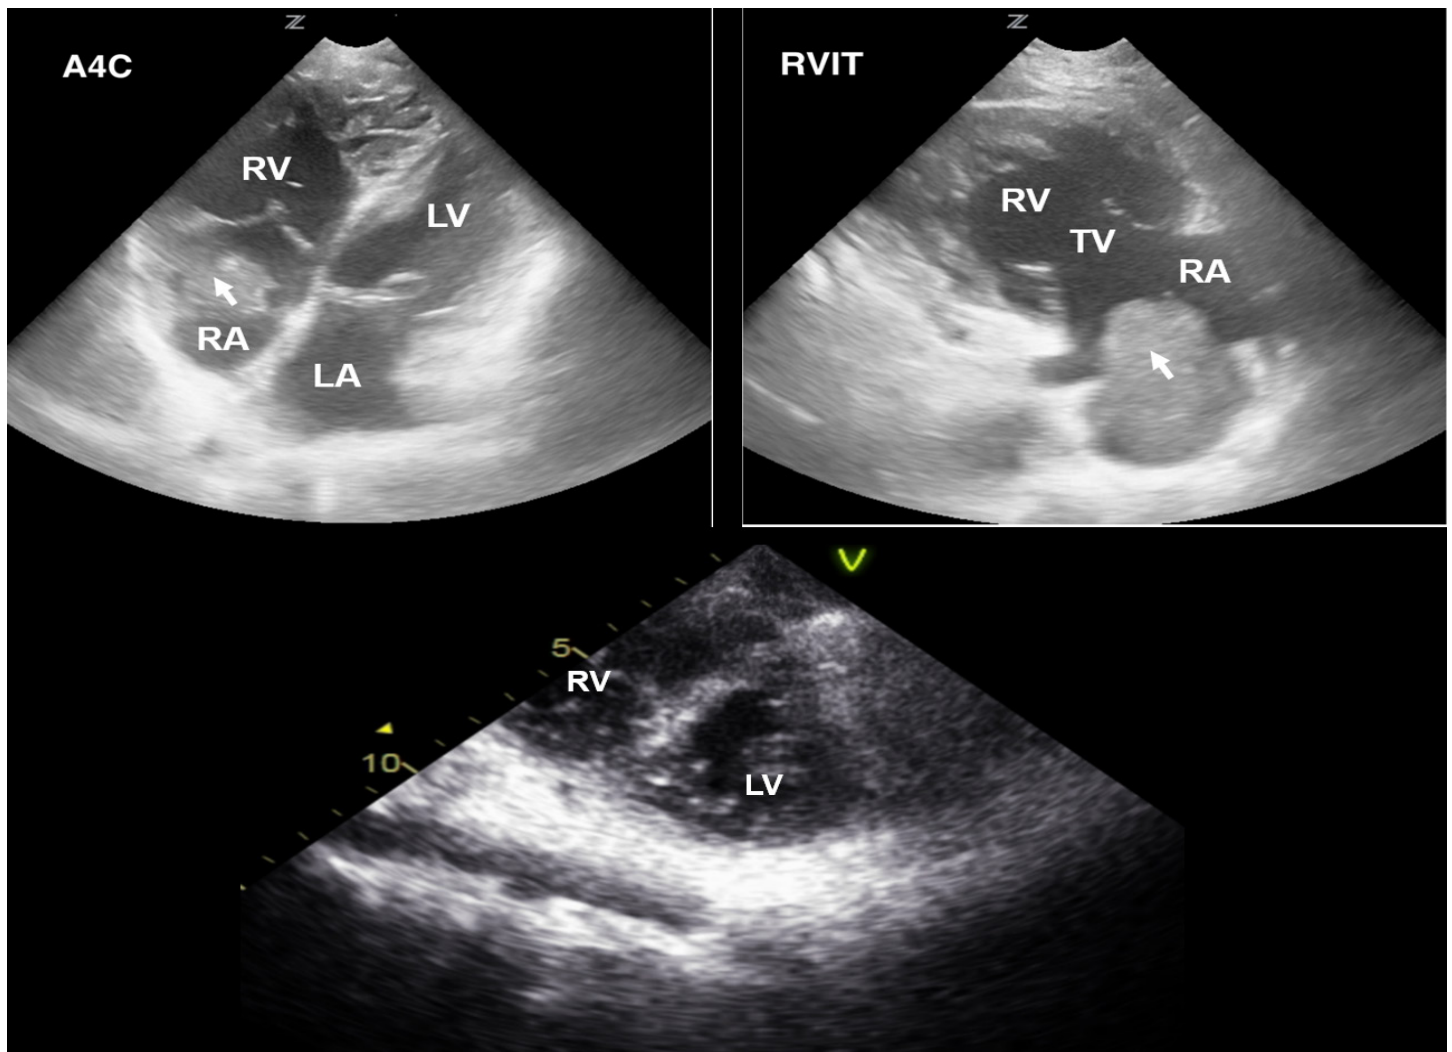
Top: Point-of-care ultrasound echocardiogram. (left: apical 4-chamber view; right: right ventricle inflow tract view); right atrial mass is noted by the arrowhead. Bottom: Formal transthoracic echocardiogram, parasternal short-axis view, enlarged right ventricle with intraventricular septum flattening in diastole consistent with pressure overload. LA, left atrium; RA, right atrium; LV, left ventricle; RV, right ventricle; TV, tricuspid valve.
